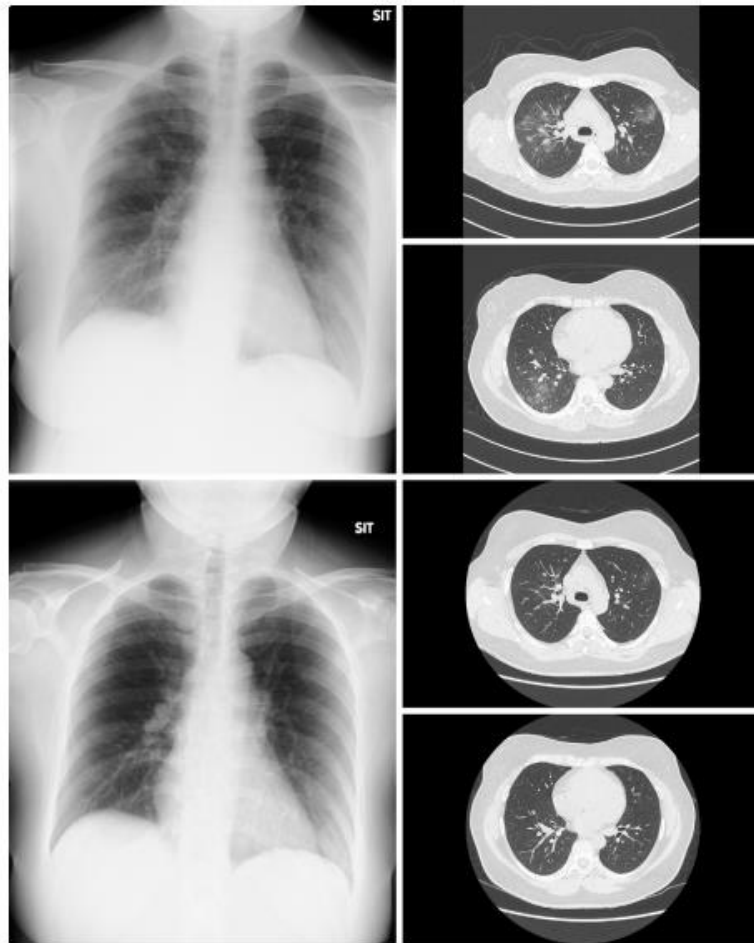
Changes in the lungs of Patient 7 on chest X-ray and a chest computed tomography (CT) scan. A patchy ground-glass opacification was found in the upper lobes of both lungs superiorly and lower lung margin dorsal superiorly on hospital day 3. On hospital Day 10, the chest CT scan showed a marked improvement in the ground-glass shadow. A: Chest X-ray on hospital Day 2; B and C: A chest CT scan on hospital Day 3; D: Chest X-ray on hospital Day 9; E and F: Chest CT scans on hospital Day 10.
